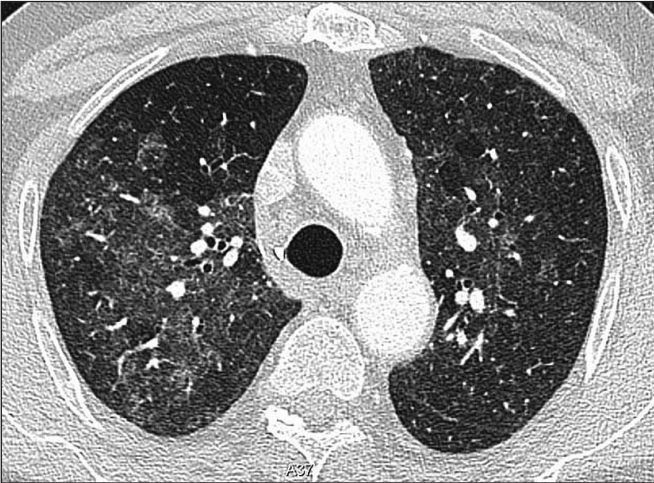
Chest CT shows Ground Glass appearance with diffuse consolidations in severe acute inflammatory process in CAP (blue arrow).
